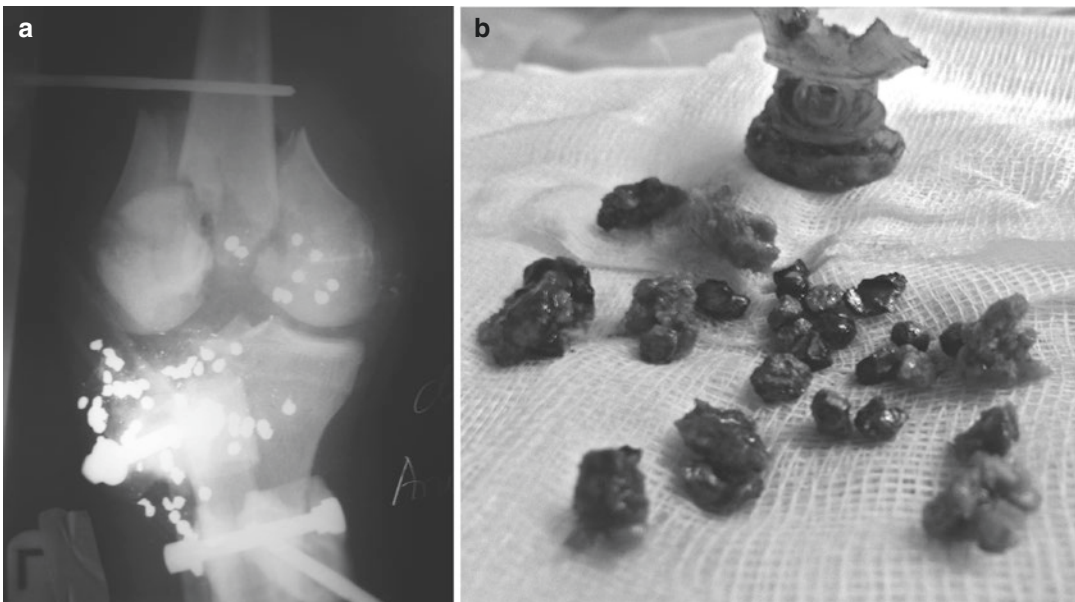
(a) X-ray of GSW of the knee and (b) metal pellets and plastic casing retrieved only after the second debridement because of insufficient initial incisions. (Courtesy of Tomoaki Atsumi, MD)
